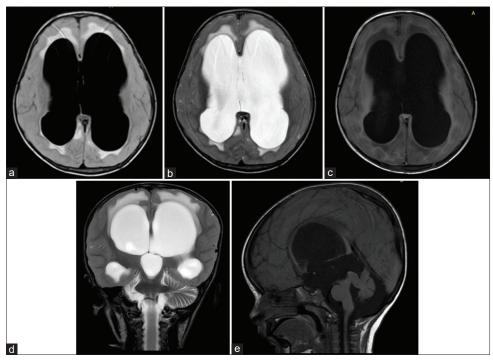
Non-communicating hydrocephalus. Axial FLAIR, T2w and T1w (a-c), coronal T2W, and sagittal T1w images demonstrate grossly dilated bilateral lateral ventricles and third ventricle (Right lateral ventricle measuring 3 cm, left lateral measuring 3.56 cm and third ventricle measuring 2.6 cm) with blunting of gyri and effacement of CSF sulcal spaces of bilateral cerebral hemispheres secondary to aqueductal stenosis at the level of midbrain. Increased T2W and FLAIR signal intensity is seen surrounding bilateral lateral ventricle s/o periventricular CSF ooze. Fourth ventricle appears prominent measuring 8 mm
